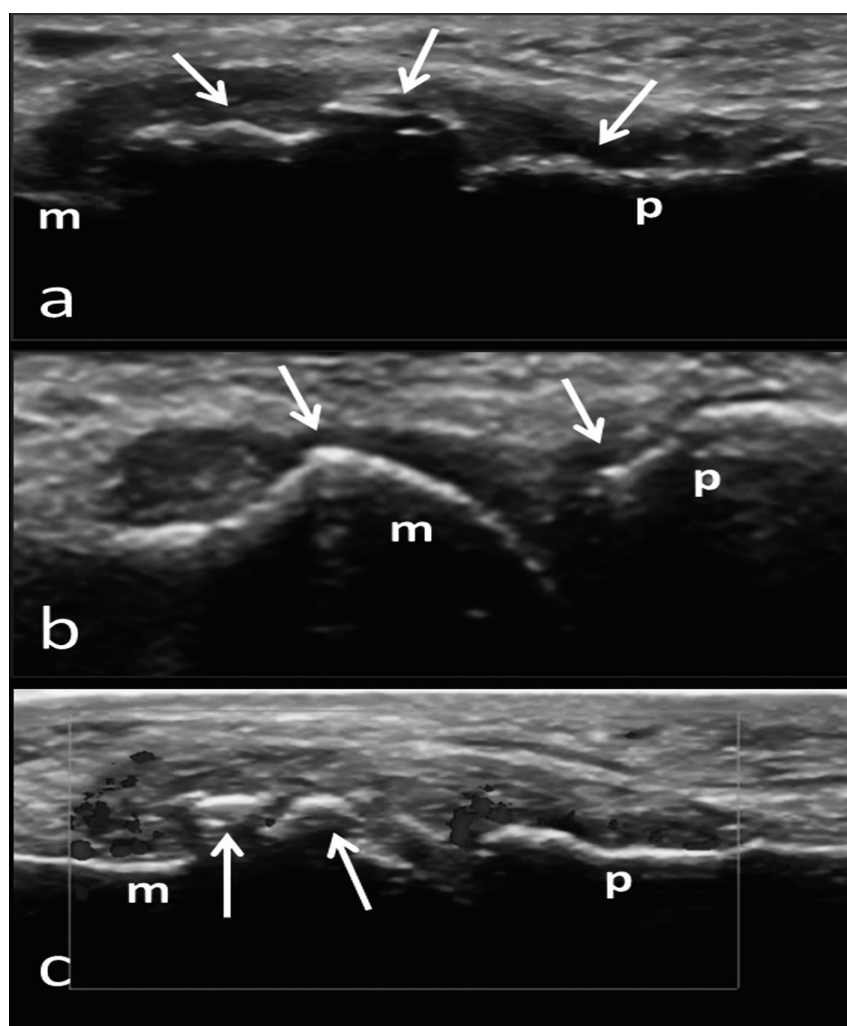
Ultrasound of the foot in osteoarthritis. a. longitudinal dorsal scan of the I MTP joint: evidence of large osteophytes (t). b. longitudinal dorsal scan of the II MTP joint: presence of synovial hypertrophy, joint effusion and small osteophytes (t). c. Power Doppler US of the I MTP joint; longitudinal dorsal scan: moderate pathological hypervascularisation of the synovial membrane, indicative of active synovitis; large osteophytes (t) are also present. m: metatarsal bone. p: proximal phalanx.
